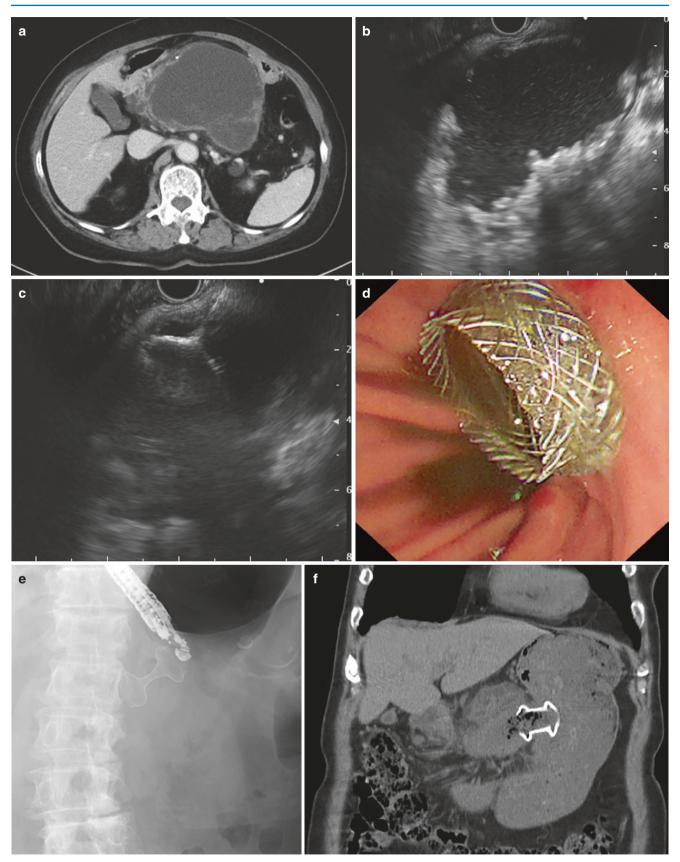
Images of the EUS-TD. (a) CT scan axial view of WON. (b) EUS image of the encapsulated WON. (c) The opened distal stent anchor is visible on EUS. (d) Endoscopic image of Hot-AXIOS. (e) Fluoroscopic image of Hot-AXIOS. (f) CT scan coronal view of Hot-AXIOS
